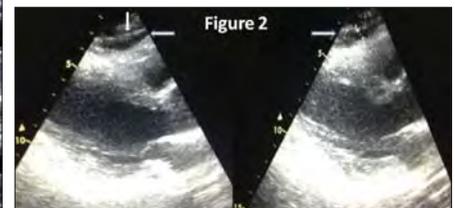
Measurement of epicardial fat thickness on the free wall of the right ventricle at end-diastole from the parasternal long-axis view by standard transthoracic 2D echocardiography
